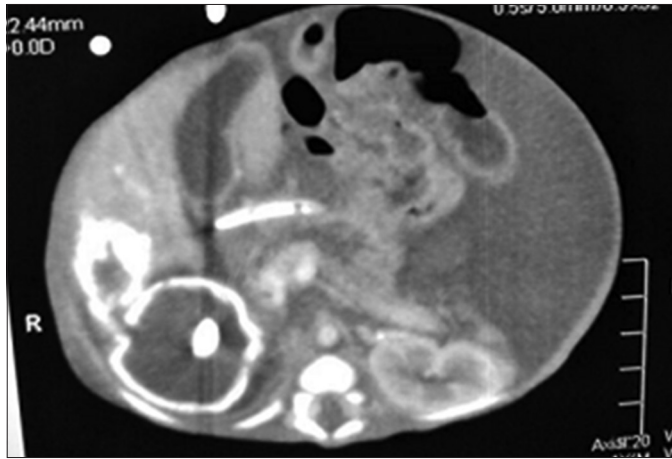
Axial computed tomography image suggestive of calcified liver abscess
